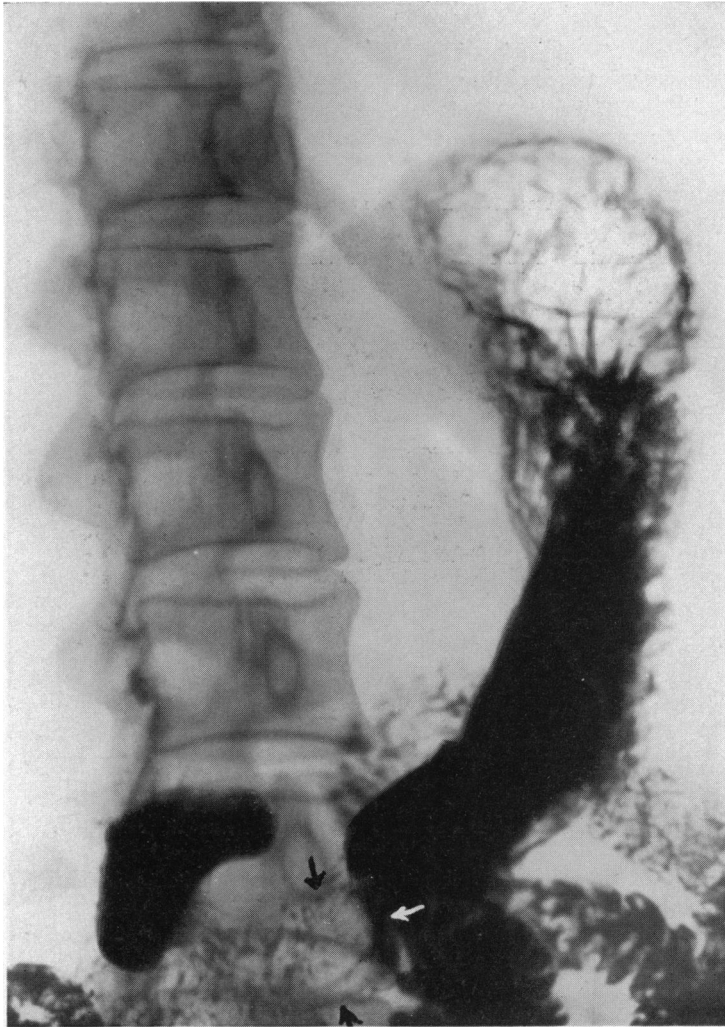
Case 7: Roentgenogram of the stomach showing tumor of the antrum.
